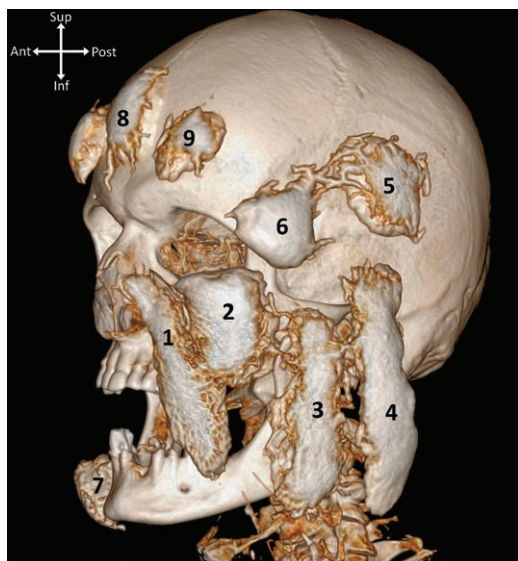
Three-dimensional reconstruction of a contrast-enhanced computed tomographic scan. The superficial (subcutaneous) facial fat compartments have been injected: superficial nasolabial (1), medial cheek (2), middle cheek (3), lateral cheek (4), superficial superior temporal (5), superficial inferior temporal (6), and jowl (7). The superficial central (8) and the superficial lateral (9) forehead compartments have also been visualized in this image.
